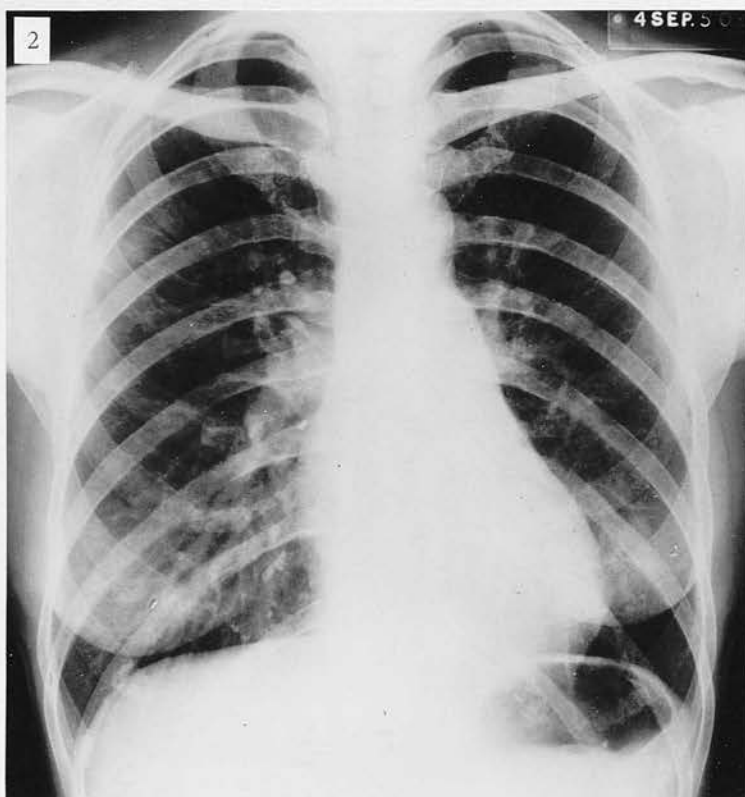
Radiograph of Case 78. Moderate Ductus in fourth decade. Development of calcification in Aortic Arch.
